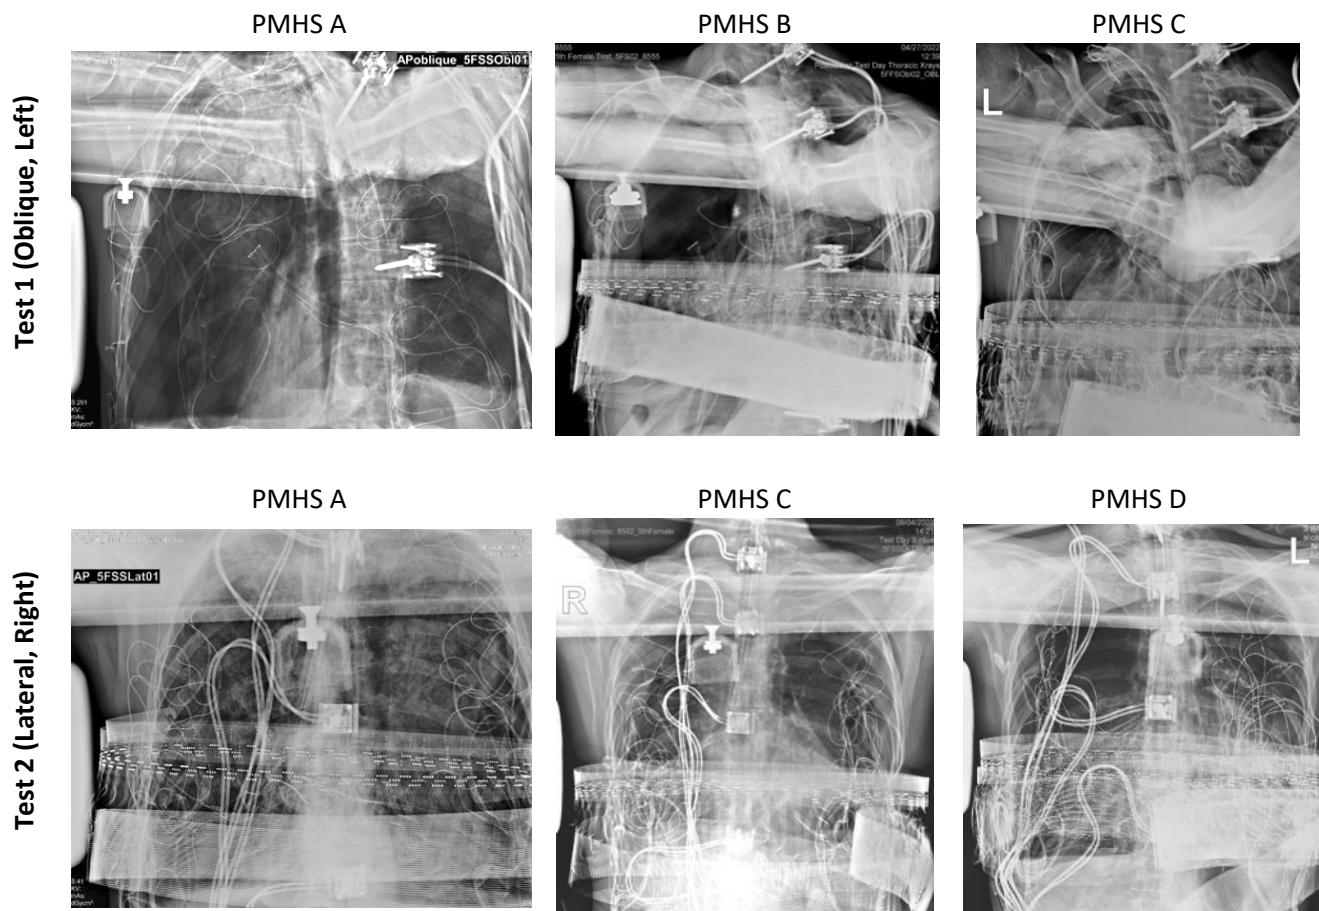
Pre-test, in-position x-rays for Condition I. Test 1 x-rays are shown in the top row and test 2 x-rays are shown in the bottom row. Impactor is shown on the left side of each image.
